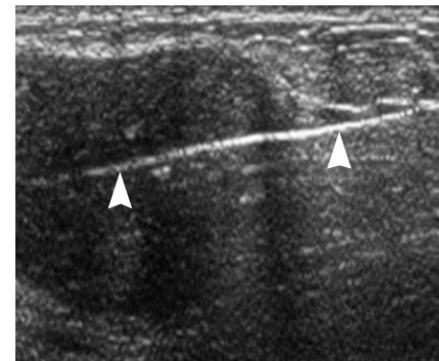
Sonogram image during ultrasound-guided biopsy shows the core biopsy needle (arrows) sampling the lesion.
